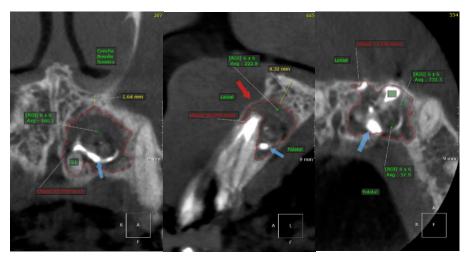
CBCT examination after 6 months post-root canal treatment, related to the lesion
